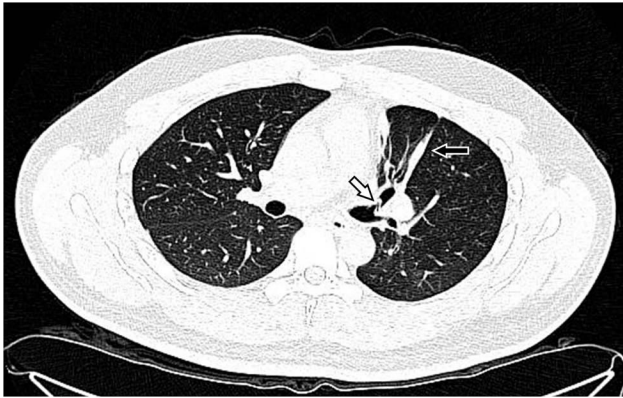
Computed tomography scan of the chest revealed an inverted V-shaped opacity in the left upper lobe bronchus (white arrow) and focal atelectasis (black arrow).
